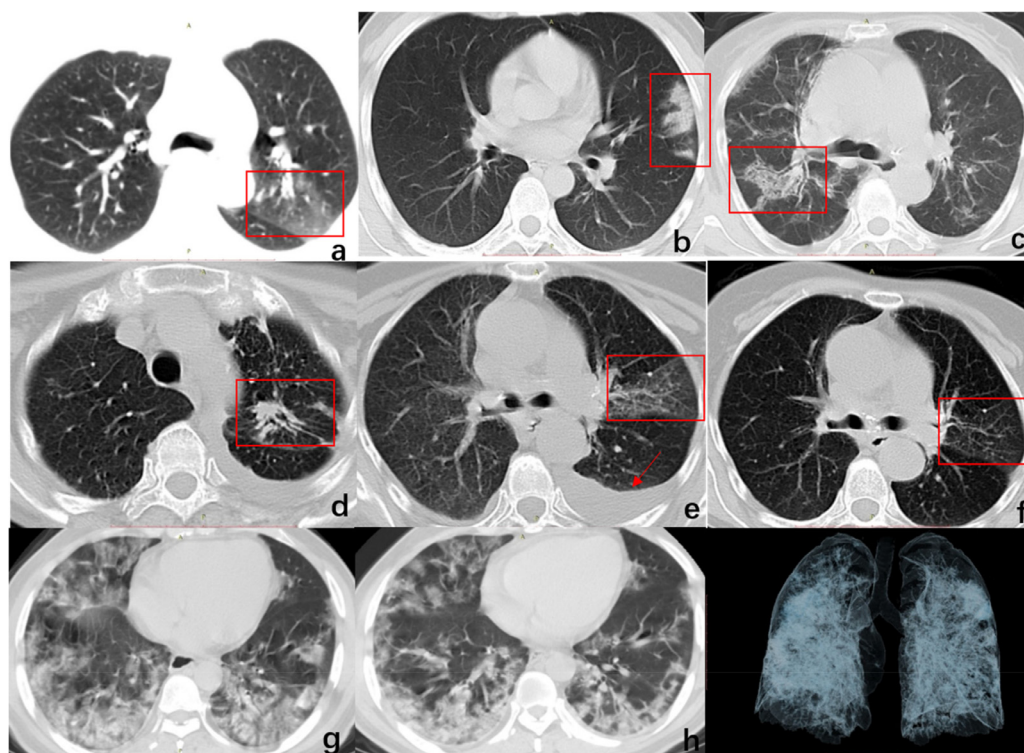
a–c Typical CT features of COVID-19. (a) GGO (b) Mix GGO and consolidation (c) Crazy paving. d–f A 77-year-old female with tuberculosis and epidemiological history, presenting with dry cough in fever clinic (d) Initial CT present tuberculosis in upper lobe of left lung. (e) Initial CT present GGO and small to moderate amount of pleural effusion in the left lung. (f) Nine days follow-up CT image present improvement at the same level. g–i A 55-year-old man with epidemiological history, presenting with dyspnea, dry cough and fatigue in fever clinic (g) Initial CT present bilateral diffuse GGO lesions. (h) Two days follow-up CT image present a little improvement at the same level. (i) 3D Volume rendering present the distribution of lesions.
